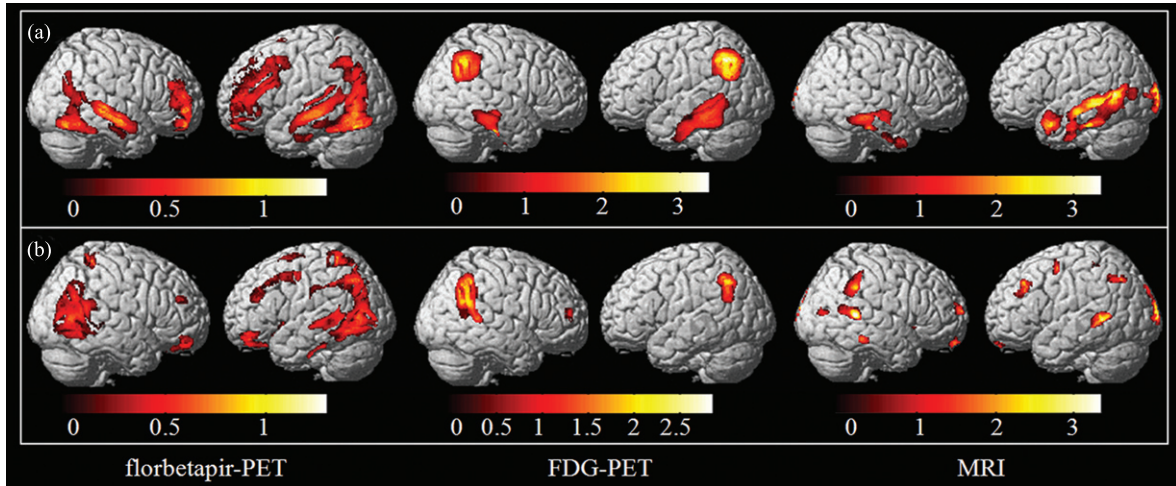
The covarying patterns of florbetapir-PET, FDG-PET, and MRI for MCI-c versus MCI-nc classification for PLS models. (a): Combined informed PLS; (b): florbetapir-(FDG+MRI) agnostic PLS.
